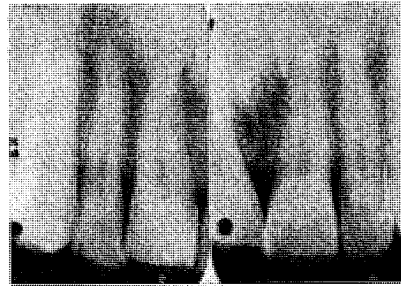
The roentgenographic picture of the maxillary anterior teeth and associated periodontal structures of a 34 year-old, presumably healthy, individual.
